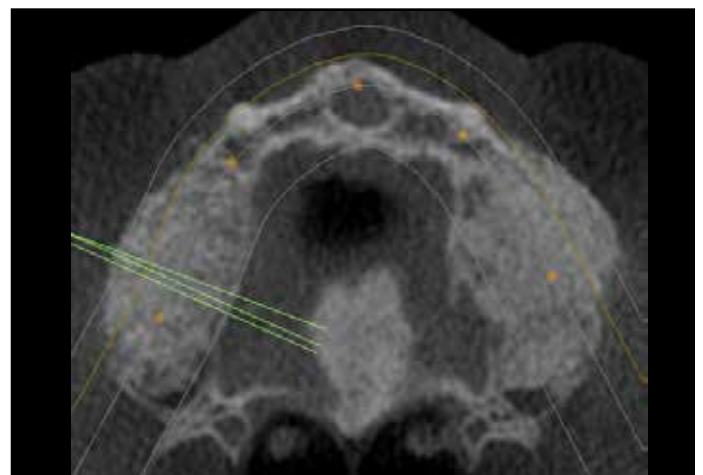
Postsurgical CBCT scan after maxillary sinus augmentations (transverse view).
